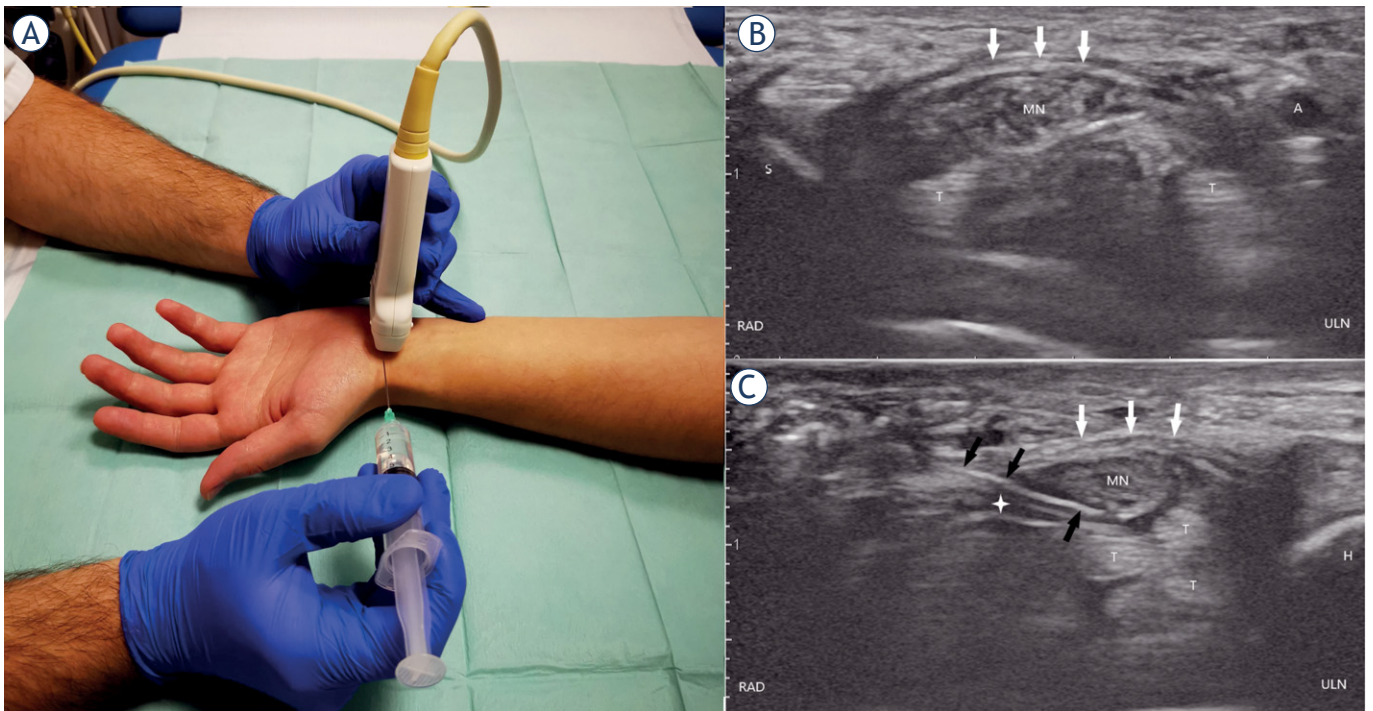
(A), (B), and (C) showing the radial approach. (A) wrist and needle positioning for carpal tunnel injection, (B) ultrasound anatomy of the carpal tunnel shown in the short axis, (C) penetrating transverse carpal ligament positioning the needle tip below the median nerve. Ultrasound of the carpal tunnel after the needle penetrates the transverse carpal ligament. Comparing figures B and C note the expansion of the perineural space marked with a white cross.
